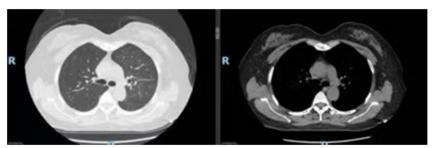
The Chest computed tomography reviewed after treatment.
